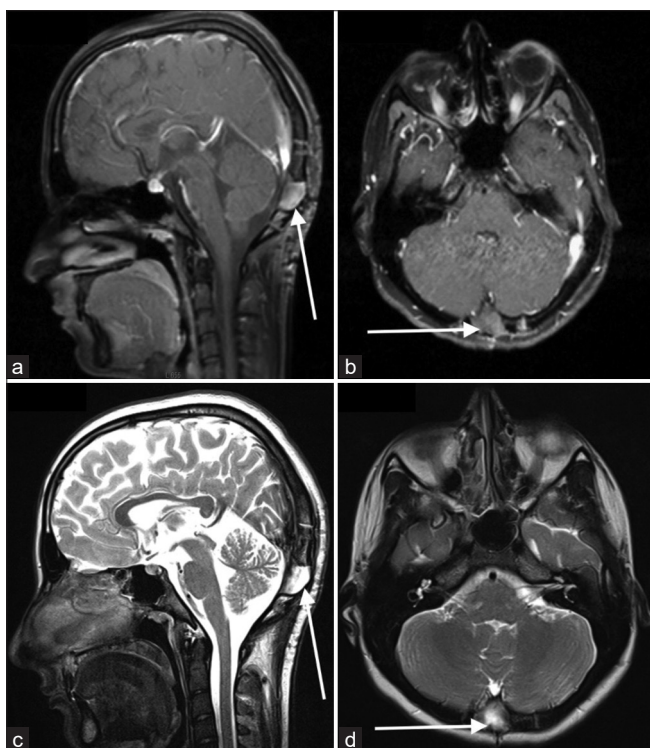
Post-operative MRI images. (a) T1 weighted contrast-enhanced sagittal and (b) coronal images showing a hypointense collection at the operative site (white arrows in panel a and panel b) with minimal contrast enhancement compared to the preoperative image. (c) T2 weighted sagittal and (d) coronal images showing hyperintense collection (white arrows in panel c and panel d) at the operative site.
